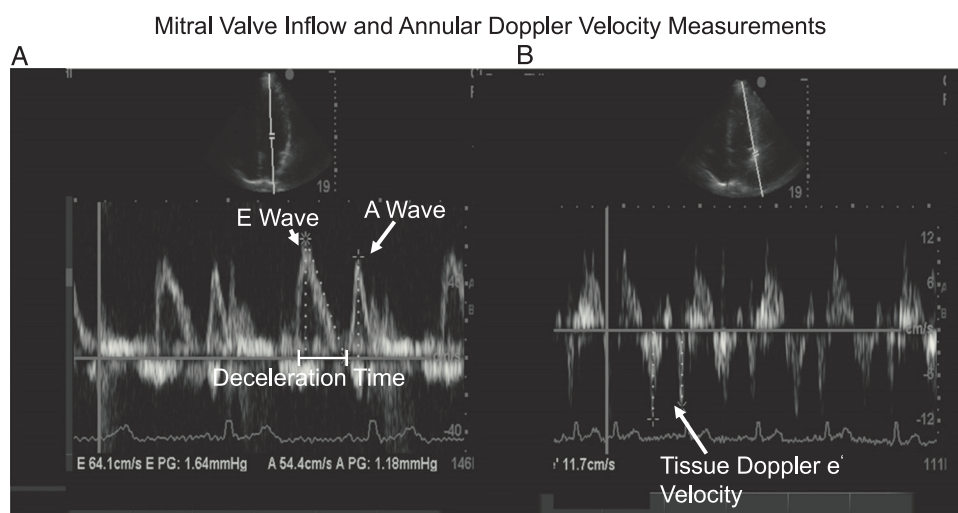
Apical four-chamber view showing both mitral inflow pulsed wave (PW) Doppler echocardiography velocities and mitral valve lateral annular tissue Doppler imaging (TDI) velocities. Measurement of these values allows for qualitative estimates of left atrial pressure. A, Mitral inflow using PW Doppler echocardiography. B, TDI of the lateral annulus of the mitral valve. In this example, the E-wave velocity is 64.1 cm/s, and the e' is 11.7 cm/s. An E/e' of 5.5 suggests normal left ventricular filling pressures, which applies to patients with ejection fractions > 40%. A wave = late mitral inflow peak velocity; e' = lateral mitral annular peak velocity; E wave = early mitral inflow peak velocity.
